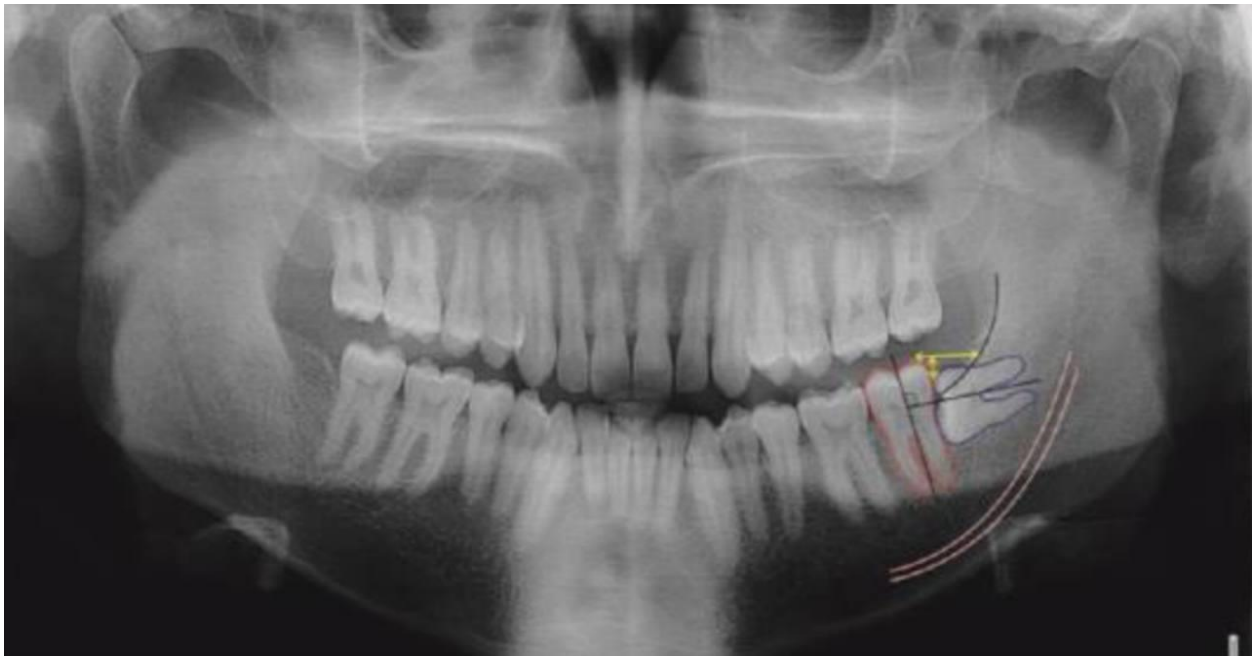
Radiological evaluation of impacted mandibular third molar by panoramic radiograph [Priya et al, 2016].
